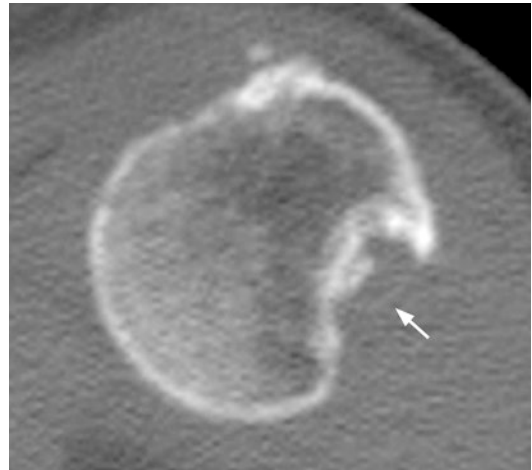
Axial CT of the shoulder through the proximal aspect of the humeral head. There is a large angulated Hill-Sachs deformity (arrow) at the posterosuperior aspect of the humeral head. Such large, angulated deformities may “engage” with the glenoid rim during external rotation precipitating anterior dislocation
